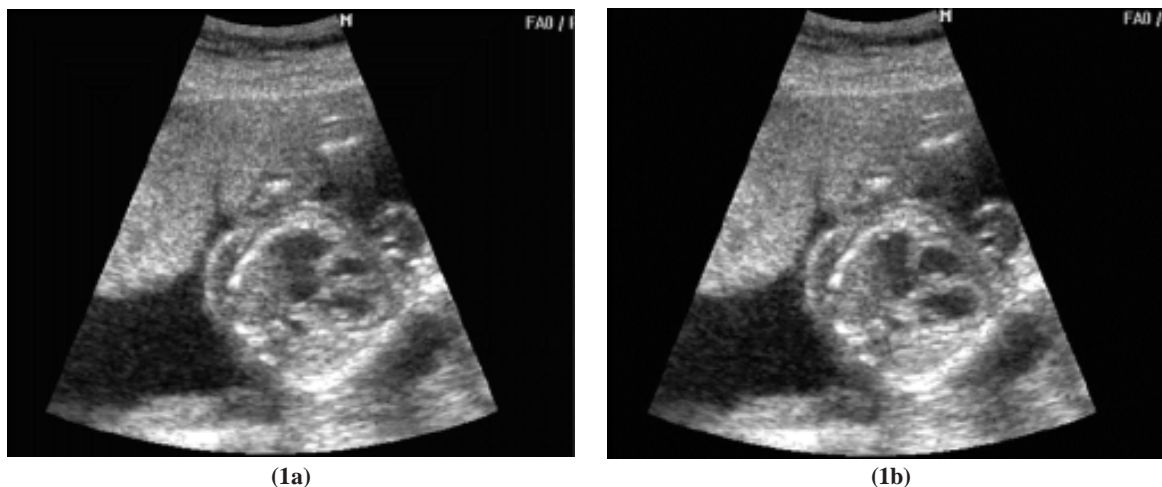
Example of 2 good quality images from the same patient obtained by using ultrasound gel (1a) compared to that obtained by using olive oil (1b)
